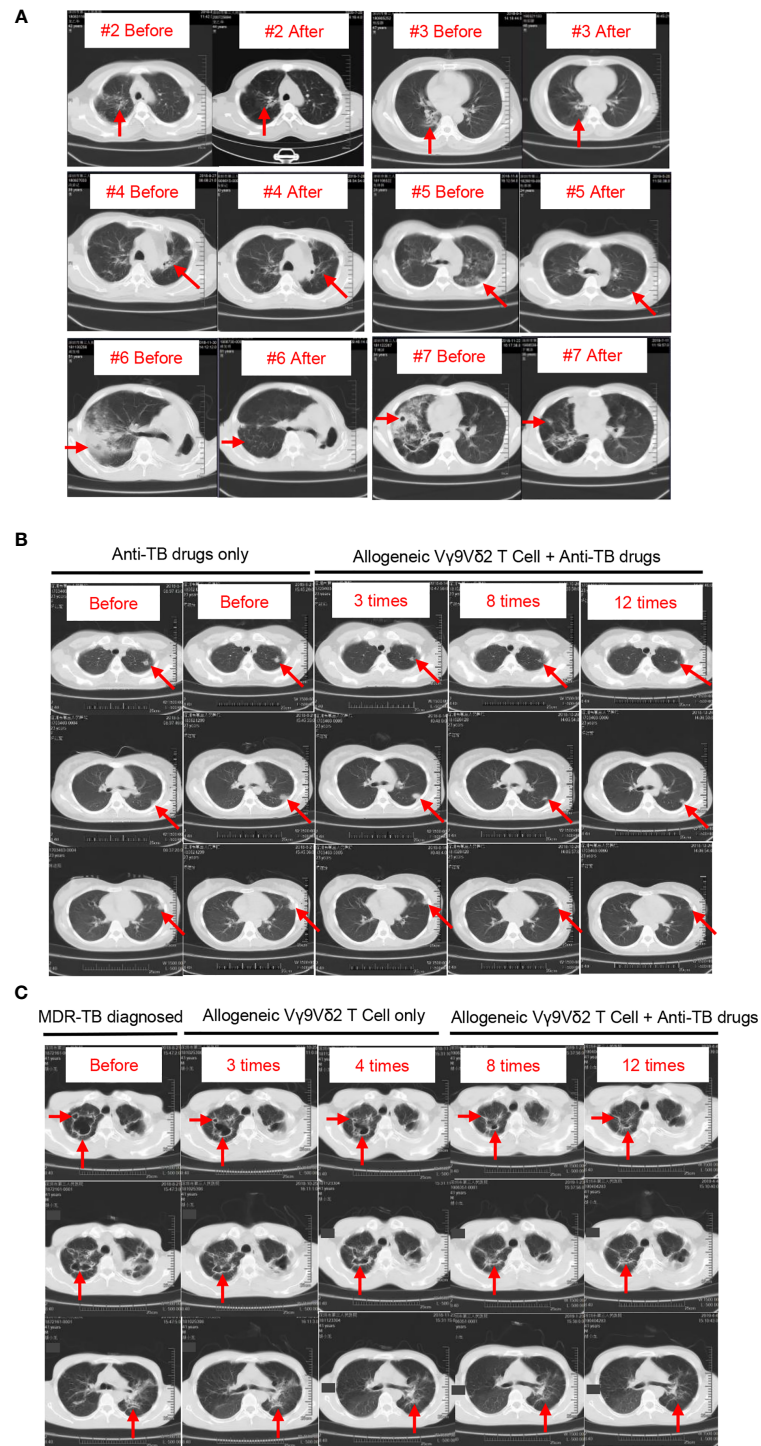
Chest CT images of the eight patients with MDR-TB before and after treatment. Pathological sites are indicated by red arrows. (A) Chest CT images of patients #2 through #6. After enrollment, these patients received Vγ9Vδ2 T-cell infusions and treatment with anti-TB drugs. CT images of two time points, one before and one after treatment. (B) Chest CT images of patient #2. This patient received anti-TB drugs before enrollment, and CT images show the progressive deterioration in lesion locations (first and second columns). After enrollment, this patient continued to receive anti-TB drugs (drug recipe not changed) plus Vγ9Vδ2 T-cell infusions. The size of pathological sites was gradually reduced with the progress of cell therapy (third through fifth columns). (C) Chest CT images of patient #8. The progressive repair of the cavitory lesion in pulmonary pathological sites after four courses of cell therapy alone (first through third columns) is shown. In the case of combined treatments with Vγ9Vδ2 T cells plus anti-MDR-TB drugs, pulmonary lesions continued to decrease (fourth and fifth columns).
